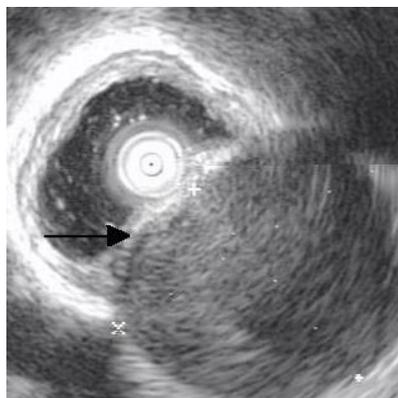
Endoscopic ultrasound (EUS) showing a hypoechoic lesion, arising within the tunica muscularis (arrow)
